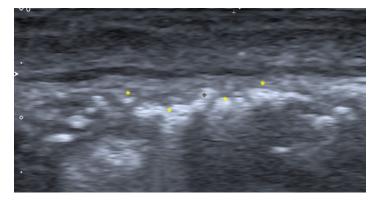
Grey scale ultrasound image, longitudinal view, malar region, shows hyperechoic deposits of hydroxyapatite forming a continuous and confluent layer.
